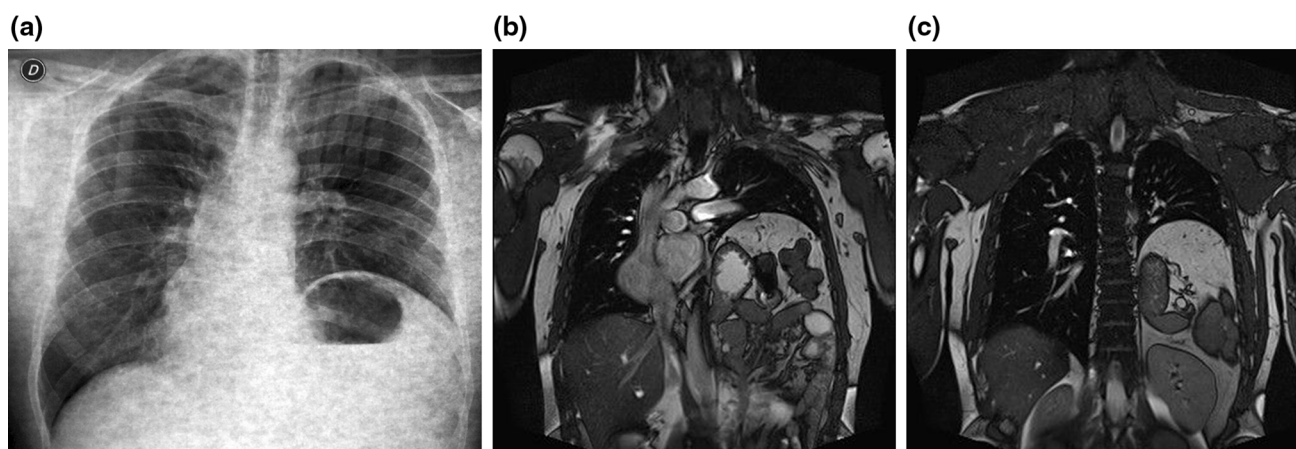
a Chest X-ray showing a significant elevation of the left hemidiaphragm with gastric distension, and right shift of the cardio-mediastinum. No significant alterations of lung parenchyma. b, c Chest MRI, coronal section, showing an elevation of the left hemidiaphragm up to a plane passing through the carina. The
